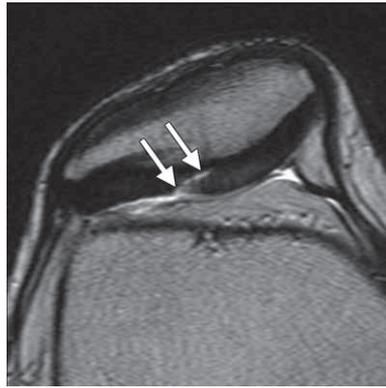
Axial 2D T2-weighted fast SE image provides excellent depiction of a focal region of deep cartilaginous delamination (arrows), with high contrast between the cartilage surfaces and synovial fluid.⁽⁵²⁾
